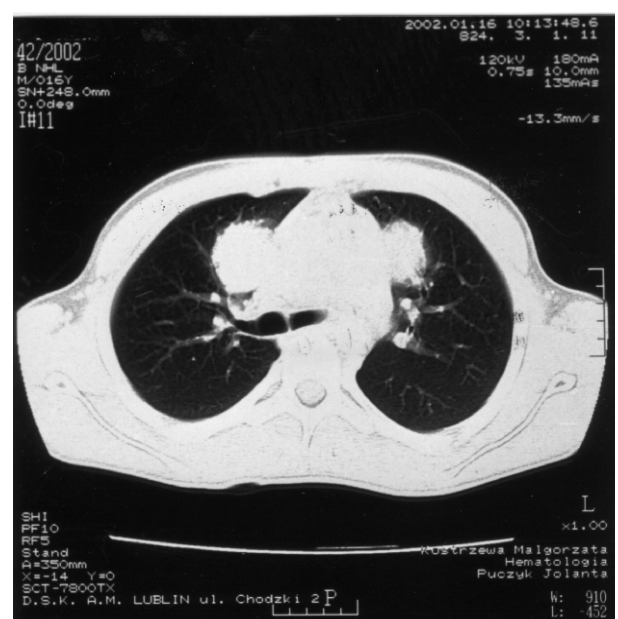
Relapse. CT scans show large mediastinal mass with multiple pulmonary metastases.
